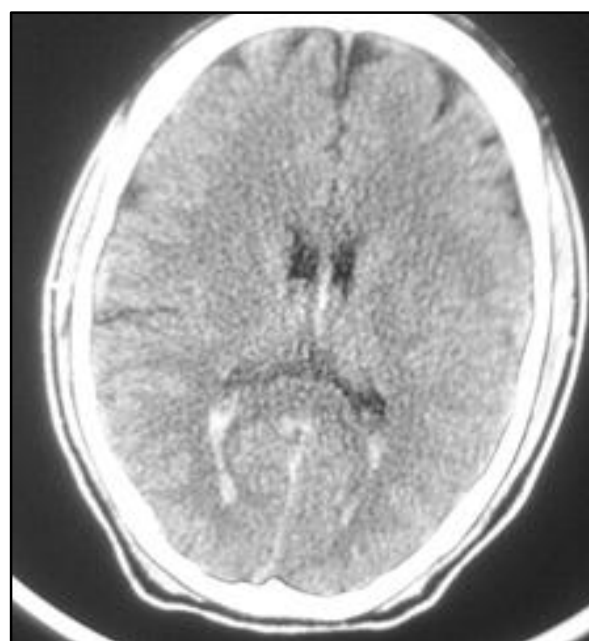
CT Axial Image showing Intraventricular Haemorrhage
